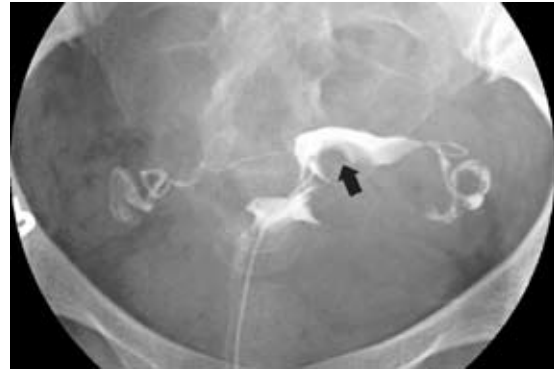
Submucosal fibroids. Hysterosalpingogram shows a distorted uterine cavity (arrowed) with loss of the normal triangular shape by multiple submucosal fibroids. The fibroids are well demonstrated in a separate ultrasonography examination, which is not shown here.
